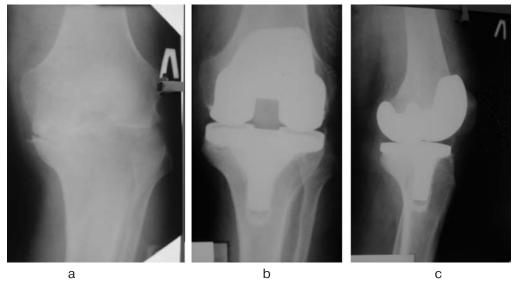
Roentgenograms of the left knee joint of the patient P. M. Before treatment (a) and after treatment (b, c)
